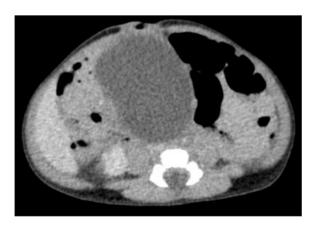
A contrast-enhanced CT demonstrates a unilocular cyst, $54 \times 47 \times 45$ mm in size, with no solid components or calcification.
